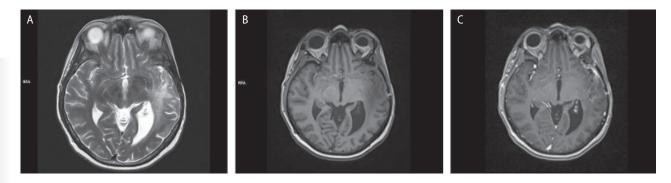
(12 June 2023) 3T MRI Siemens Magnetom Skyra axial images. A. In left temporal lobe postoperative and post-radiotherapy lesions, hyperintense on T2 sequence with relevant regression; BC. Important regression has also been on T1+C sequences
